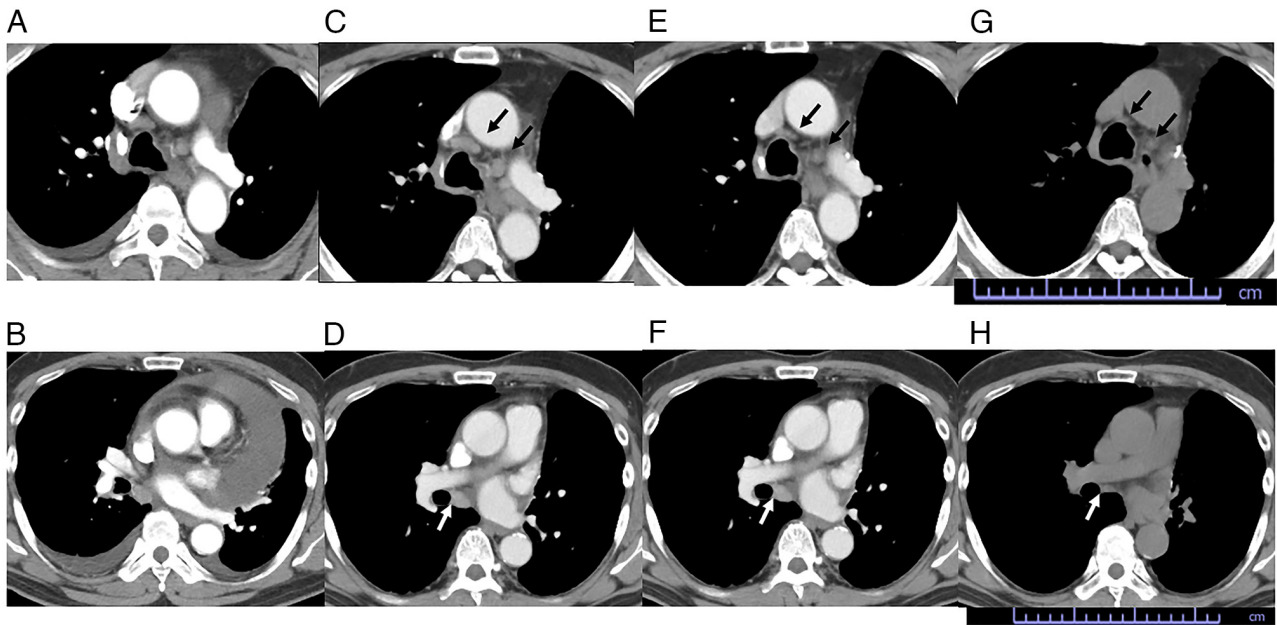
Chest CT images before and after initiating tepotinib treatment. (A and B) Following fourth-line chemotherapy, the tumor grew rapidly, and caused cardiac tamponade and thus required immediate drainage. (C and D) A CT scan immediately prior to tepotinib treatment revealed enlarged mediastinal lymph nodes (arrows). At 4 weeks following the initiation of tepotinib treatment, (E and F) the mediastinal lymph nodes shrank rapidly (arrows) and (G and H) the response was maintained for 2 months (arrows indicate shrunken lymph nodes).
